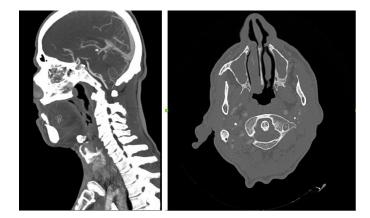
2nd patient pre-operative CT CT: Computed tomography
